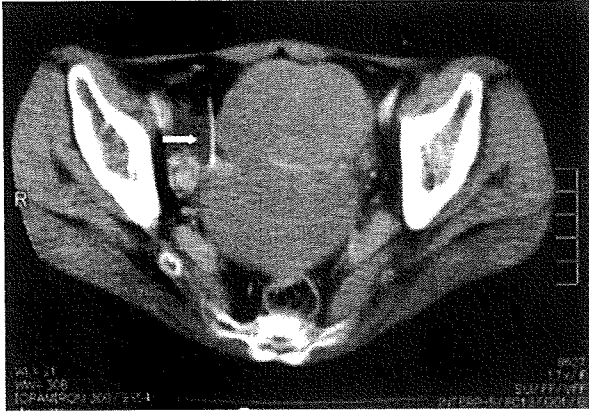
A computed tomography scan showing pelvic masses. The ventriculoperitoneal shunt is indicated by an arrow.
